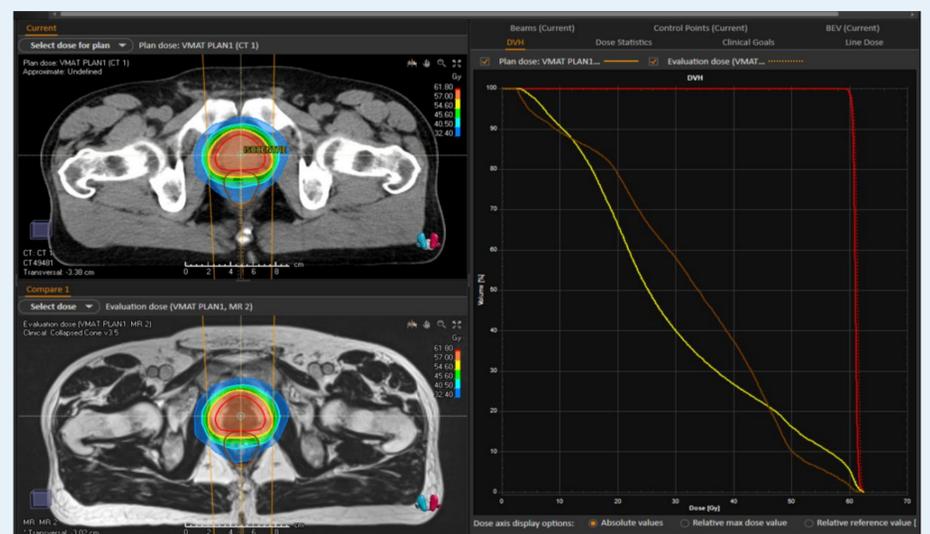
Top left - Dose distribution on CT, Bottom left – Dose distribution on MRI, Right - DVH for PTV (red), bladder (yellow) and rectum (brown) CT based statistics solid lines, MRI statistics dashed lines.
